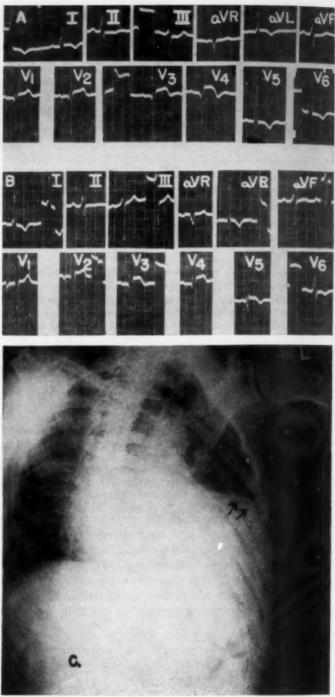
Ventricular aneurysm diagnosed by physical examination and confirmed by roentgenogram. Acute myocardial infarction in 1946.
